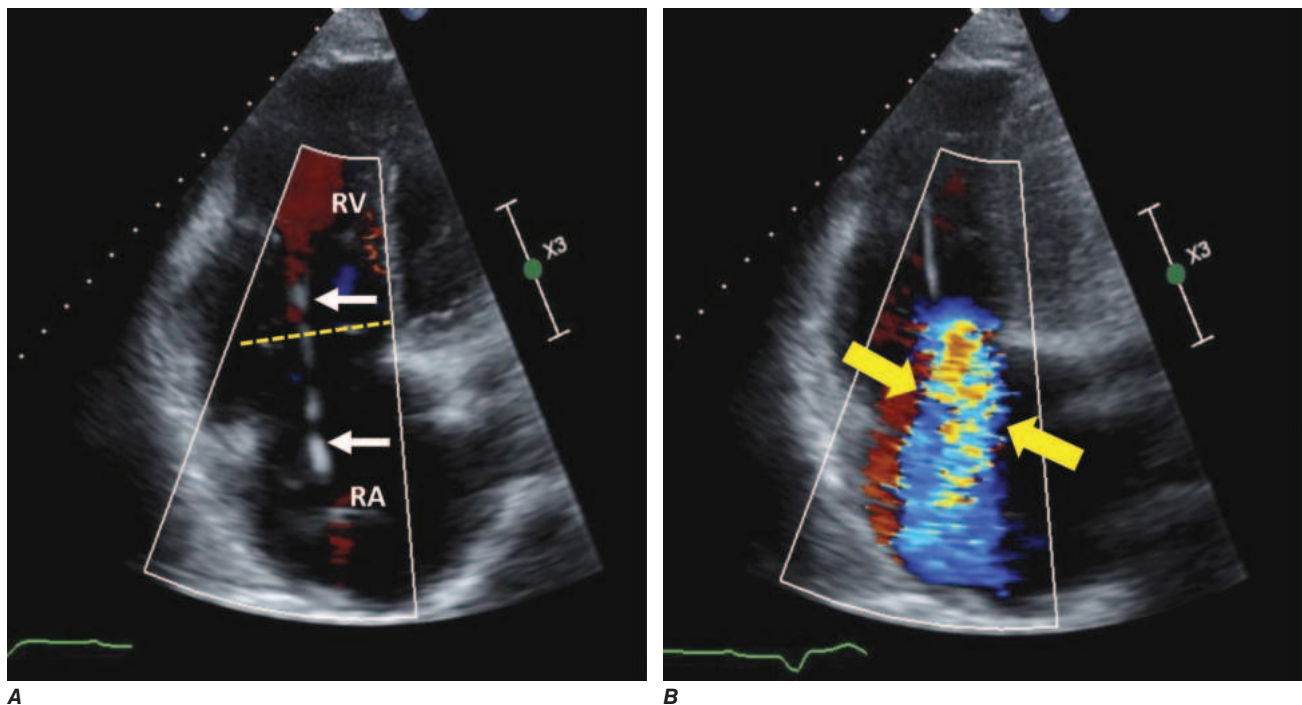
Tricuspid regurgitation. A. Transthoracic apical two-chamber view showing right atrium on bottom and right ventricle on top. There is a pacemaker lead (white arrows) traversing the tricuspid valve. The plane of tricuspid valve closure is shown by the dotted yellow line. B. Corresponding color flow Doppler image in systole shows a broad jet of severe tricuspid regurgitation (between the yellow arrows) refluxing into the right atrium. RA, right atrium; RV right ventricle.
